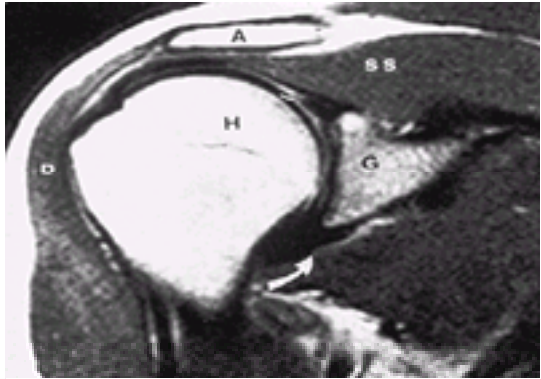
MRI of shoulder demonstrating normal anatomy (arrow, labrum; H, humerus; D, deltoid; A, acromion; SS, supraspinatus; G, glenoid).
